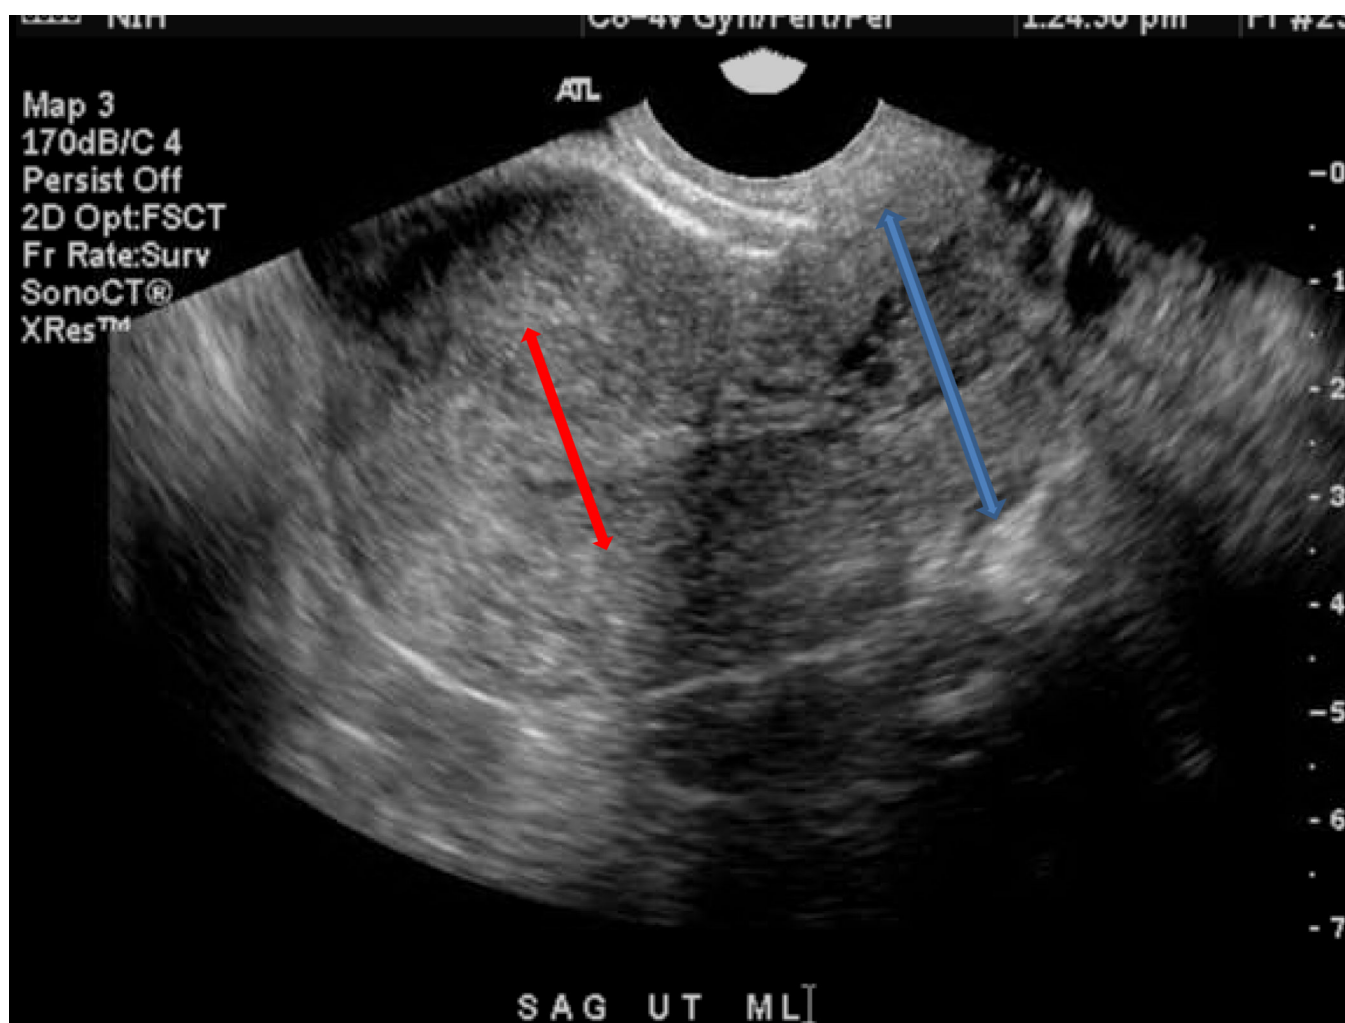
Transvaginal ultrasound of the uterus (sagittal view) demonstrating a thickened endometrial lining (red arrow), increased junctional zone, and enlarged cervix (blue arrow) with multiple cystic structures.
